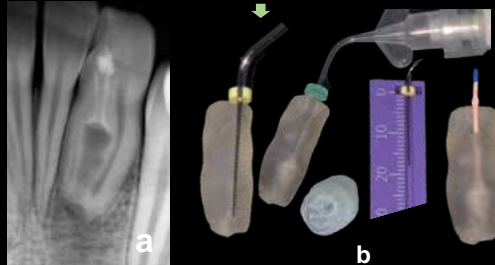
(a), x-ray at 4 months. (b), Obturation practice.
